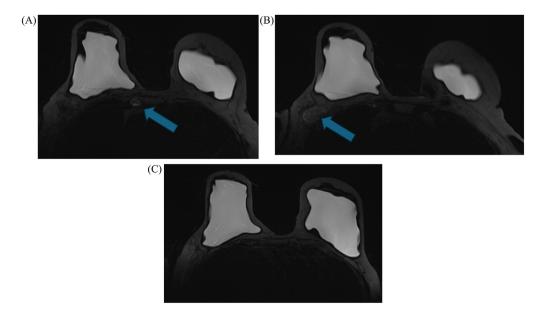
Axial water suppressed subtraction T2-weighted image of both breasts demonstrates an enlarged internal mammary chain lymph node with hyperintensity suggestive of silicone (A), as well as a large, T2-hyperintense mass in the right axilla (B). Additional axial water suppressed T2 image indicates that both breast implants remain intact (C).
